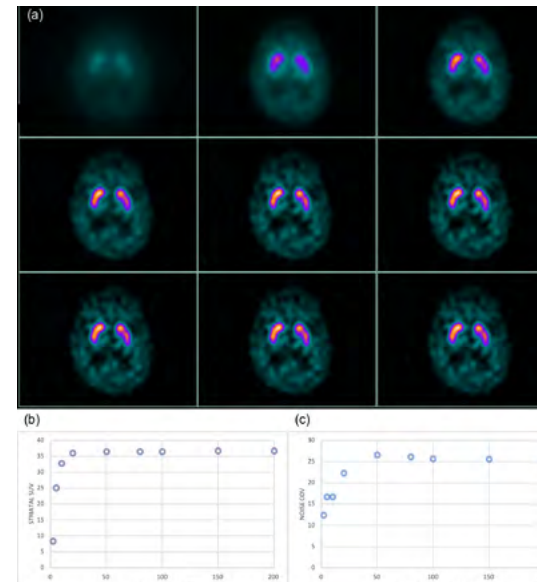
(a). I-123 ioflupane SPECT images reconstructed with increasing number of iterations and subsets in the OSEM reconstruction. Charts showing the change in quantitative value in the lesion (b), and the increasing level of noise in the background (c) with increasing number of EM-equivalent iterations. EM-equivalent iterations is the product of iterations and subsets
